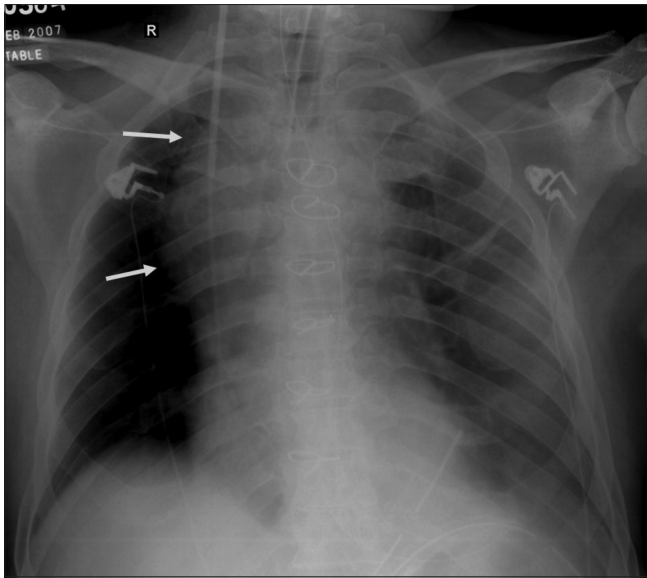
Frontal chest radiograph following placement of a central venous catheter shows right paratracheal soft tissue with a bulging contour (arrows), due to mediastinal hematoma
